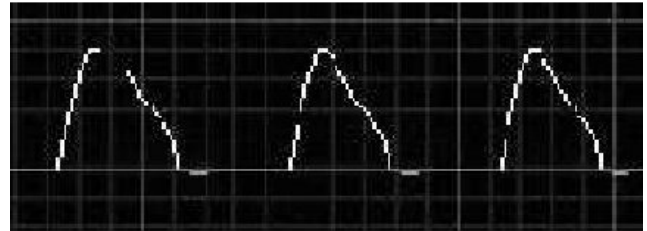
The Doppler waveform in left ventricular failure
